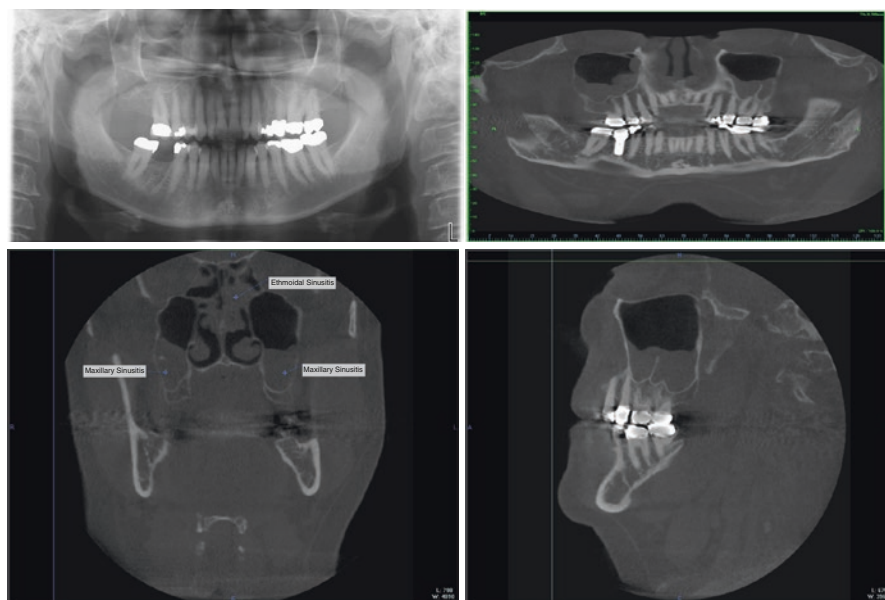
Panoramic and CBCT images showing sinusitis
